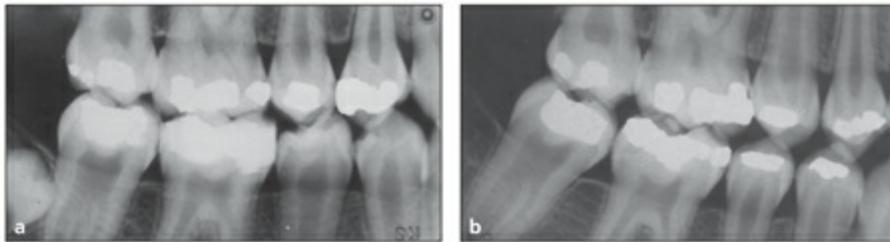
(*a and b*) Bitewing radiographs of a patient with XLH rickets. Note the enlarged pulp chambers, large root canal systems, and pulp horns that extend to the dentinoenamel junction. (Reprinted from Bender and Naidorf¹³⁹ with permission.)
